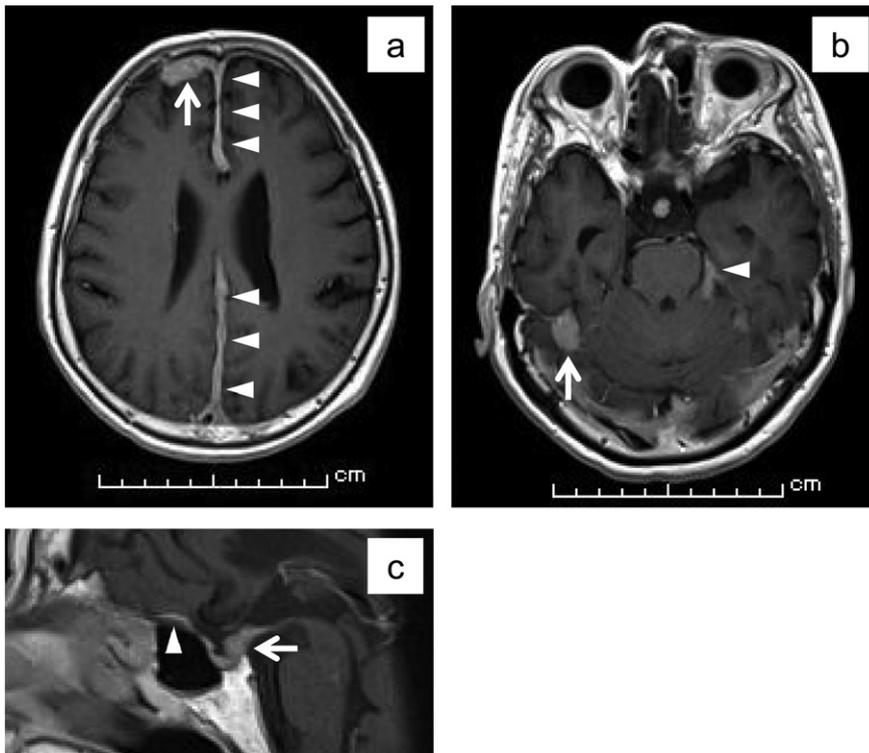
Pretreatment brain MRI images (a–c). Before the steroid treatment, horizontal gadolinium (Gd)-enhanced T1-weighted MRI images show homogeneously enhanced masses on the falx cerebri (a, arrow), right tentorium cerebelli (b, arrow). In addition, slightly thickened falx cerebri (a, arrow heads) and tentorium cerebelli (b, arrow head) are noted. Sagittal view shows Gd-enhanced swollen pituitary infundibulum, posterior hypophysis (c, arrow) and thickened sellar diaphragm (c, arrow head).
